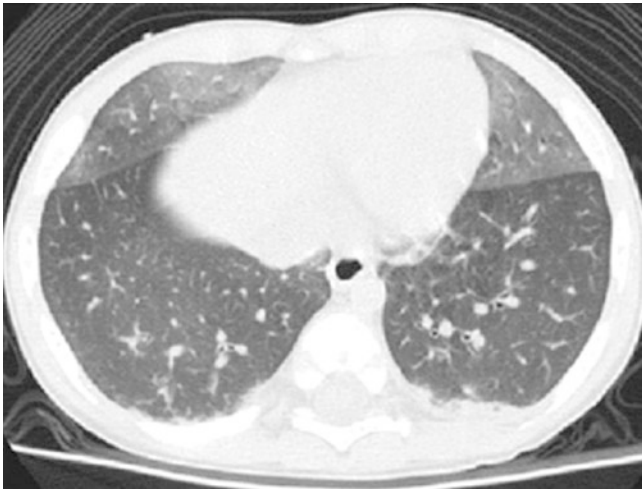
CT study with lung window settings demonstrates ground-glass opacity in the right middle lobe and lingula in a 23-month-old infant with biopsy proven NeHi
